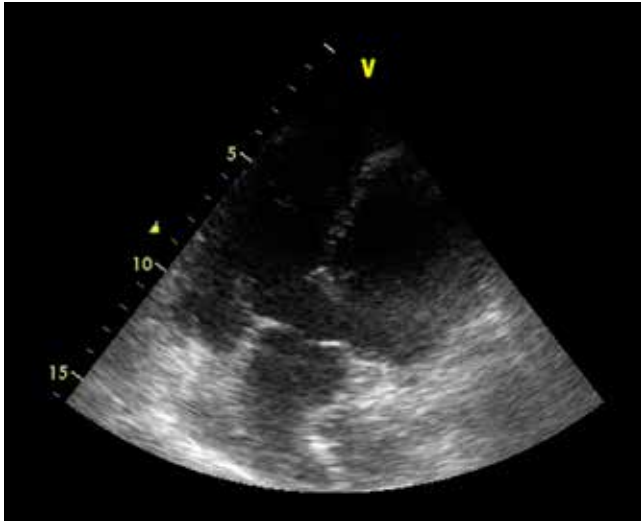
Transthoracic echocardiography showed ventricular septal defect, overriding aorta with biventricular connection and dilated ascending aorta
